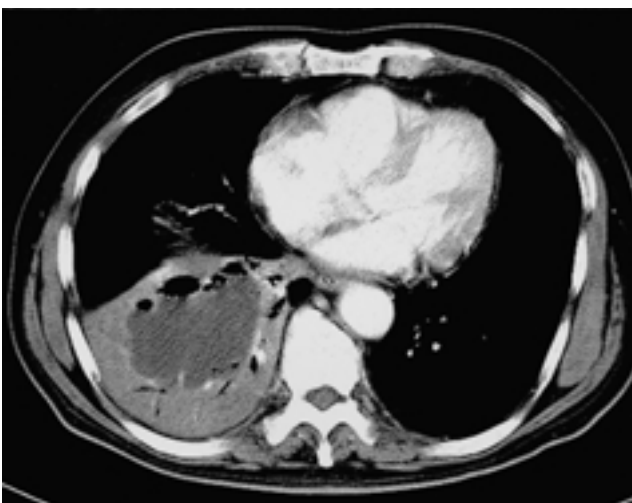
Chest CT shows air space consolidation with air-fluid level in right lower lung field.
